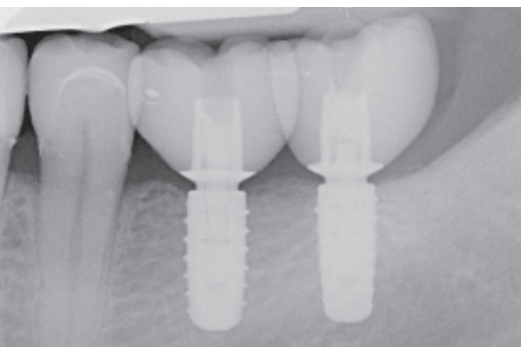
The radiographic outcome immediately after the placement.
